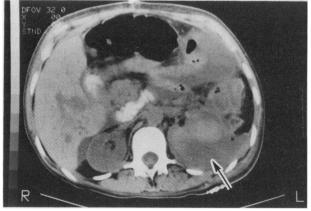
Computed tomography scan without contrast enhancement, through left renal hilus: outline of left kidney is lost within fluid collection that fills perirenal and posterior pararenal spaces; gas bubble (arrow) suggestive of abscess.
